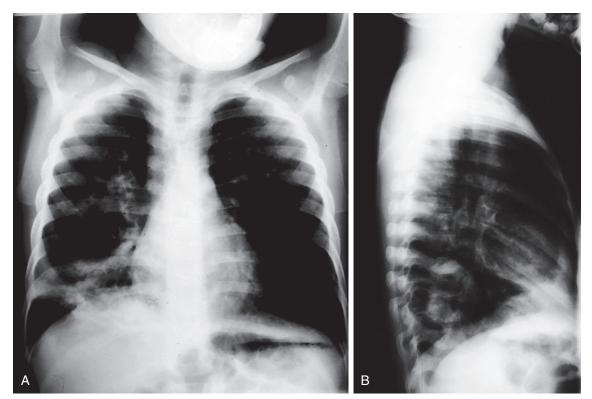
Progressive primary pulmonary tuberculosis (endobronchial). This 8-year-old girl initially had fever, cough, and mild tachypnea. She was treated with antibiotics for presumed bacterial pneumonia but showed only partial clinical improvement. Repeat radiographs obtained 1 month later showed progression. A purified protein derivative test was then done and was positive. A and B, She has a collapse–consolidation lesion involving the right lower lobe, with a primary cavity. (*Courtesy Ellen Wald, MD, University of Wisconsin Children's Hospital, Madison, Wis.*)
